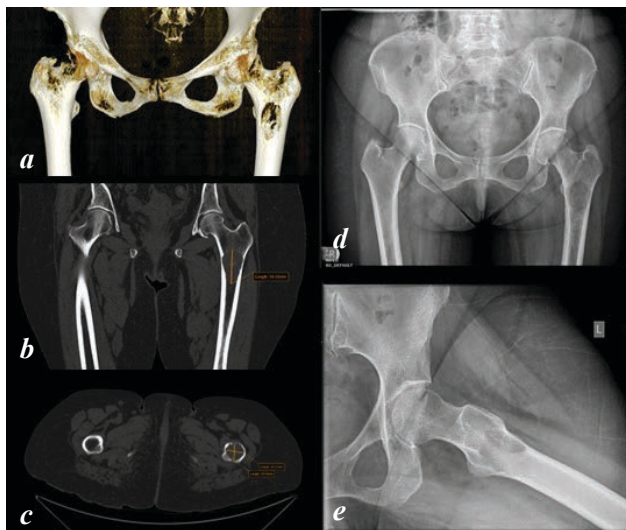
CT scan & Xray of femoral region with bone lytic lesion.
